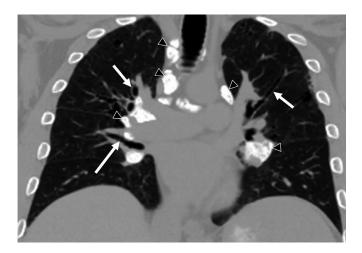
Coronal noncontrast CT shows prominent calcified mediastinal and hilar adenopathy (black arrowheads). There is additional prominent bronchiectasis (straight arrows).
